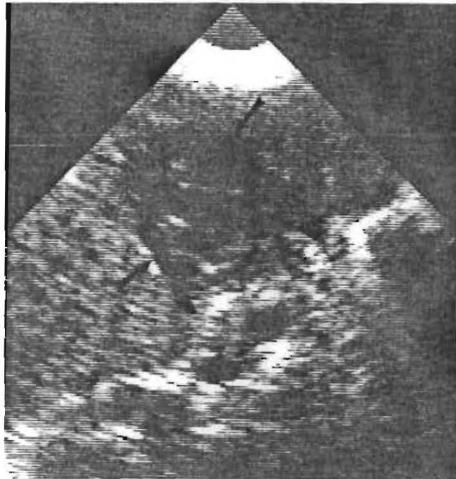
Focal area of hepatic parenchymal inhomogeneity (arrows) on sonogram of 3-year-old girl with hepatic artery thrombosis. At retransplantation, pathology revealed infected infarct.
